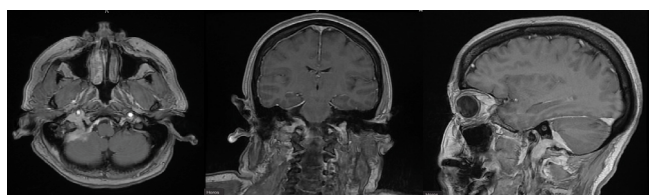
Contrast-enhanced T1-weighted MRI of the brain in the axial, coronal and sagittal sections demonstrates a lesion in the right jugular foramen, extending to the internal auditory meatus, cerebellopontine angle, and extracranially.
